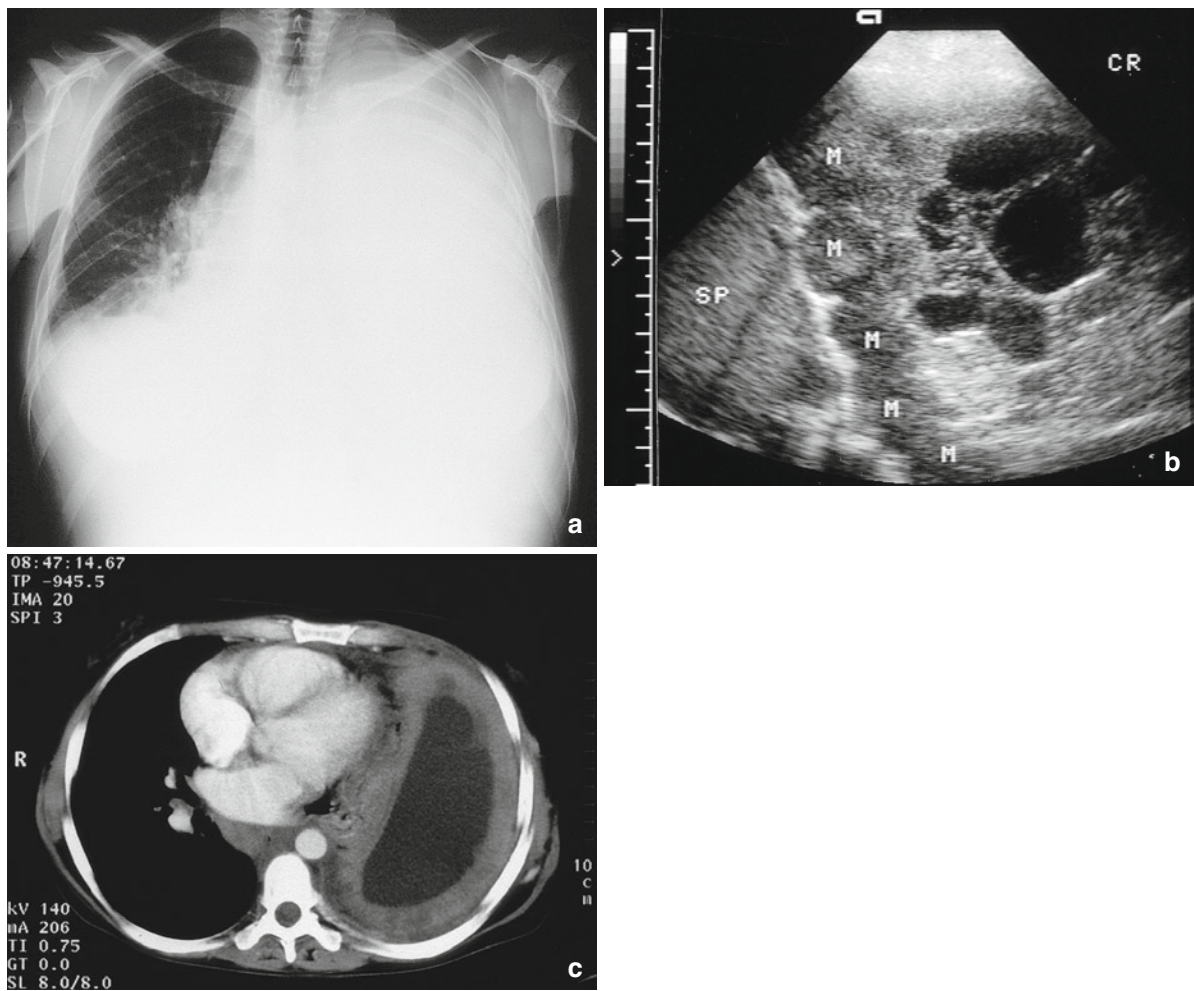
A 58-year-old man with bronchial carcinoma. (a) Chest radiograph. Complete opacity of the lung on the right side. (b) Ultrasonography. The subcostal transhepatic ultrasound
